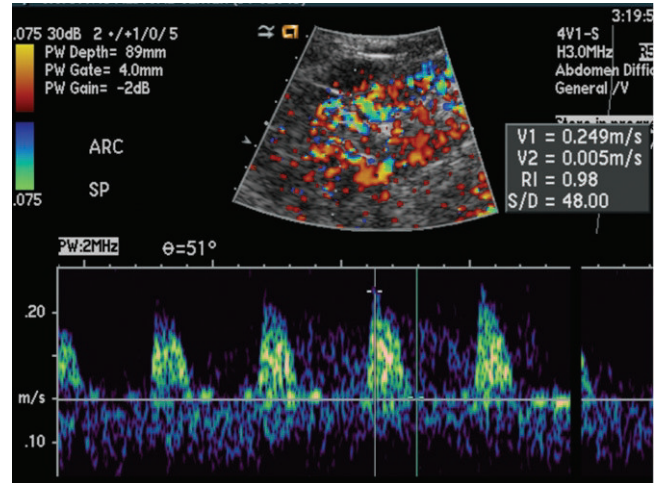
Intrarenal Doppler waveform demonstrates high resistance waveform with absent diastolic flow reflective. High resistive index of 0.98 is calculated, but in reality is probably 1.0.
